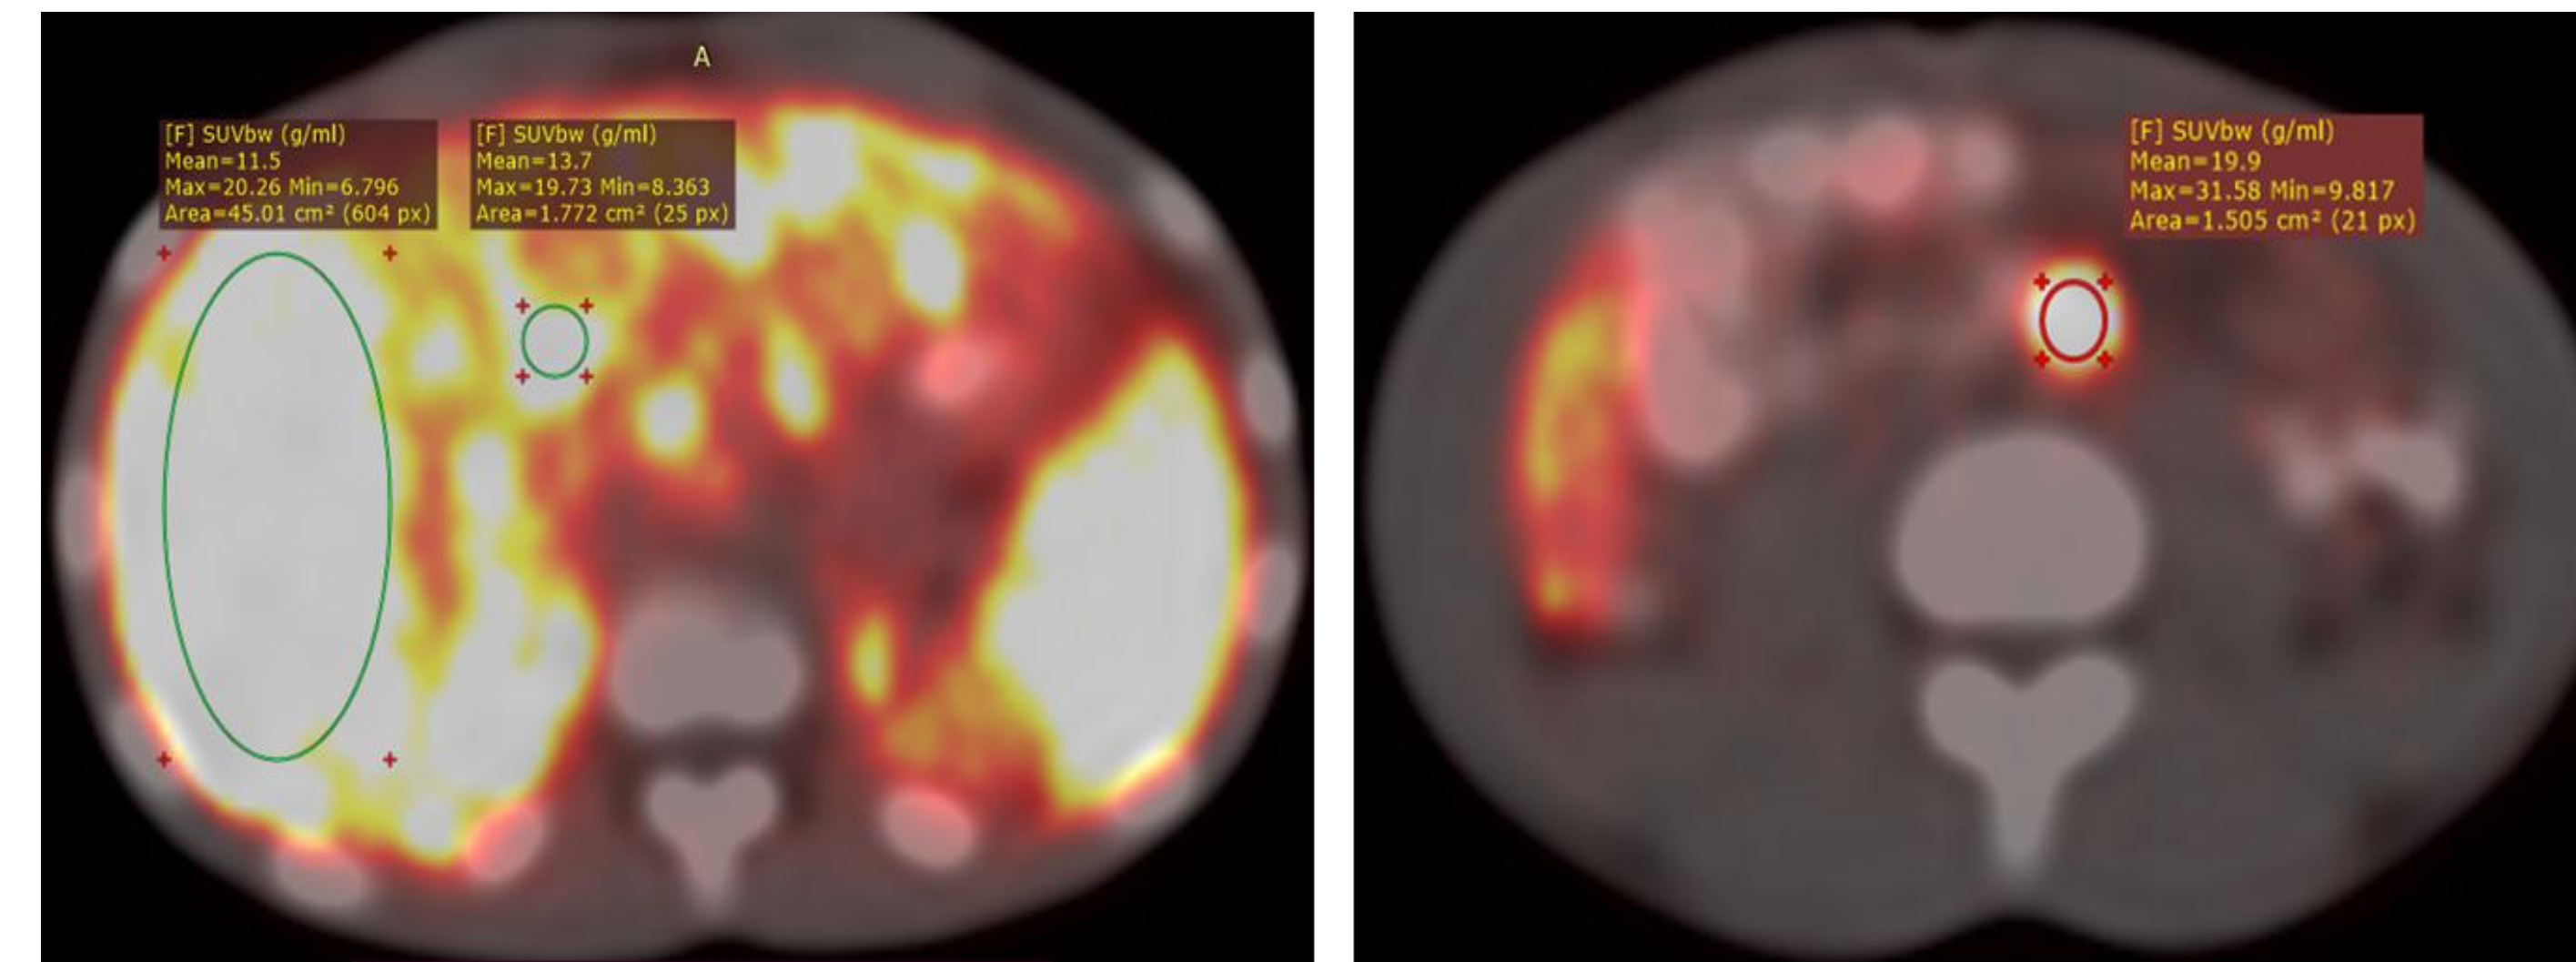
68Ga-DOTA peptide PET/CT showed uptake from the liver metastases (SUVmax:25) and other abdominal lesions (SUVmax:31)
